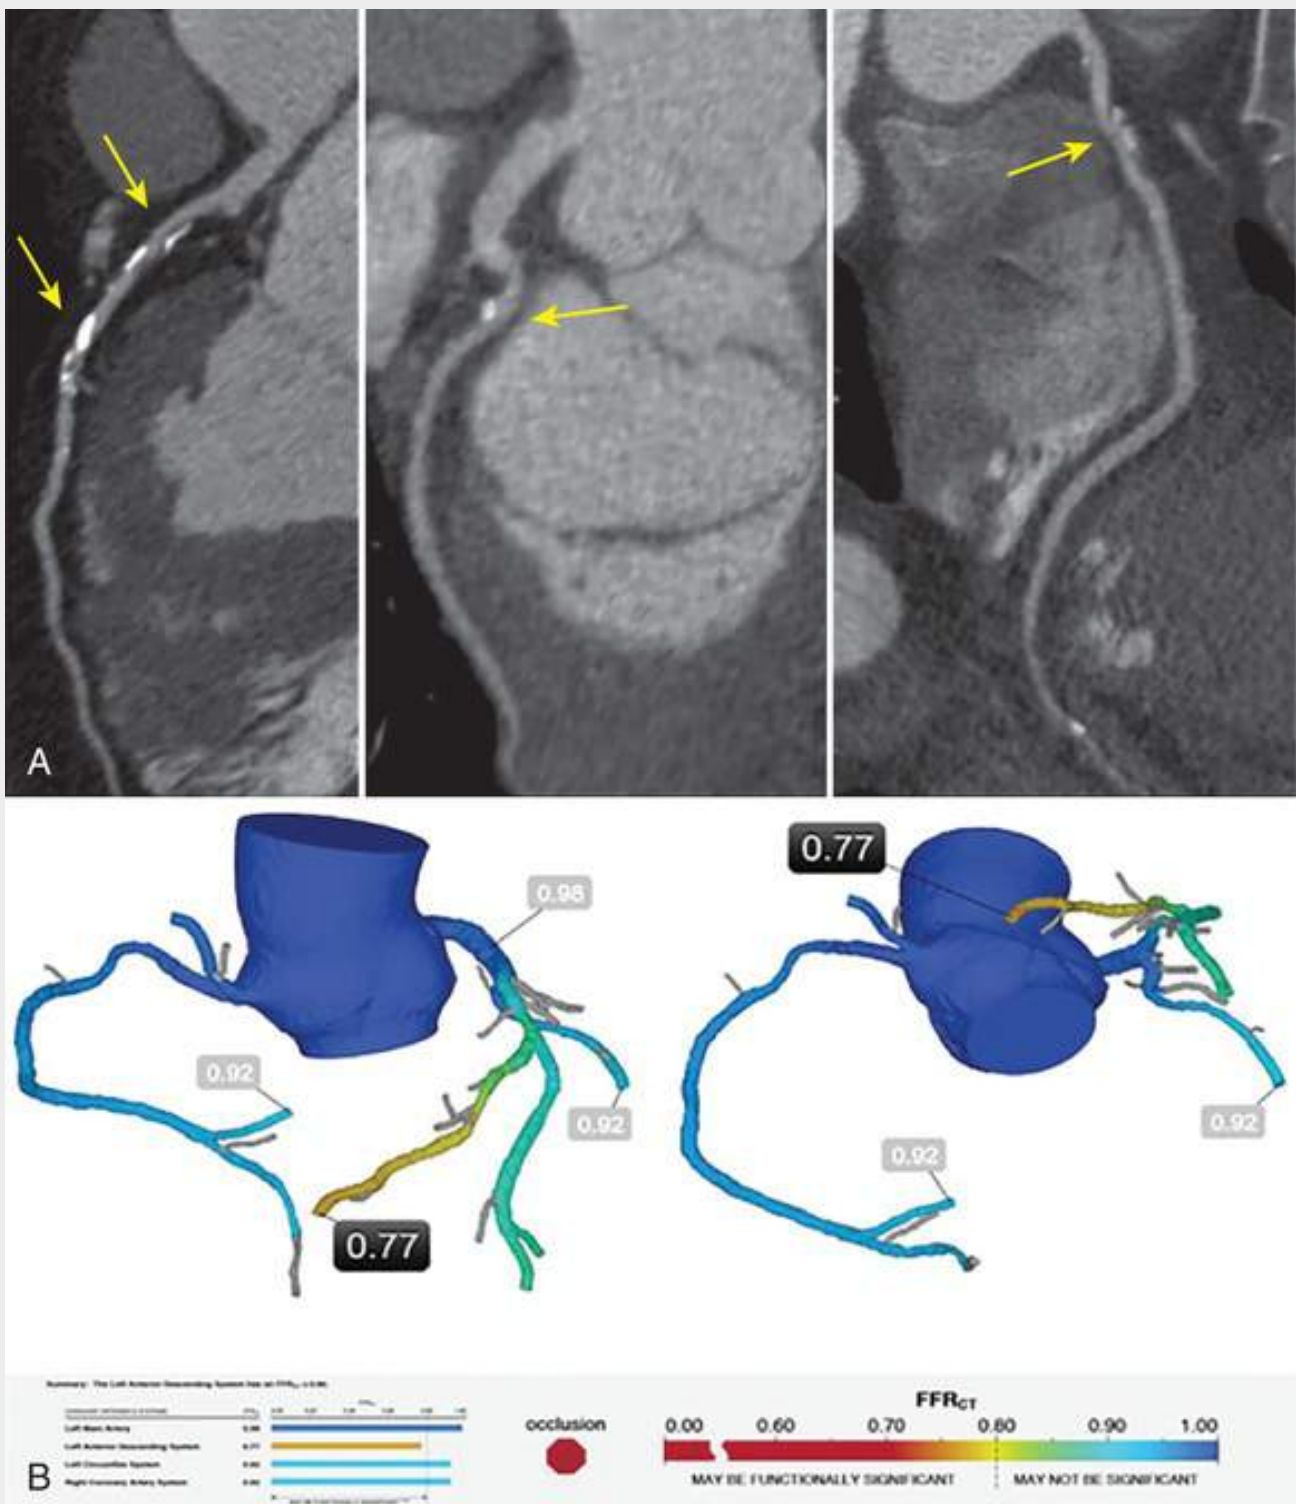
Fractional flow reserve derived from CCTA (FFR_{CT}). A, CCTA demonstrates moderate stenosis in proximal portion of left anterior descending artery (LAD). Midportion of LAD cannot be adequately visualized due to severe calcified plaque. Mild nonstenotic plaque is noted in left circumflex artery and moderate stenosis in midportion of right coronary artery. B, FFR_{CT} demonstrates significant ischemia in LAD (FFR_{CT} 0.77) that spares the diagonal branch (FFR_{CT} 0.92). Note that FFR_{CT} allows for interrogation of ischemia at all points in the coronary artery tree.
